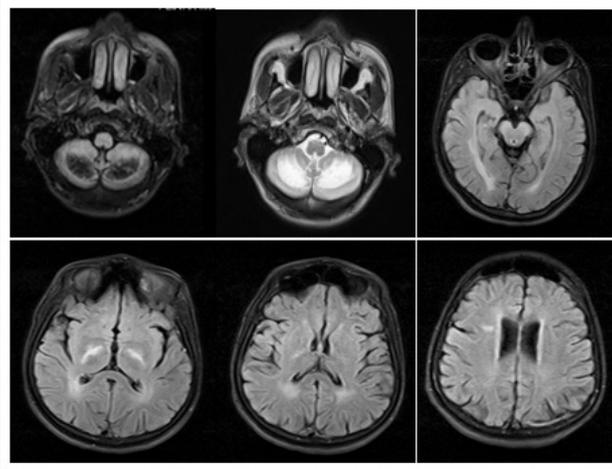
Axial Brain MRI of the patient (A) FLAIR sequence showed hypointensity of dentate nuclei (B) T2 Sequence showed hyperintensity of dentate nuclei. (C, E, F) Axial FLAIR sequence showed abnormal hyperintensity of white matter and (D) abnormal hyperintensity of bilateral basal ganglia.
